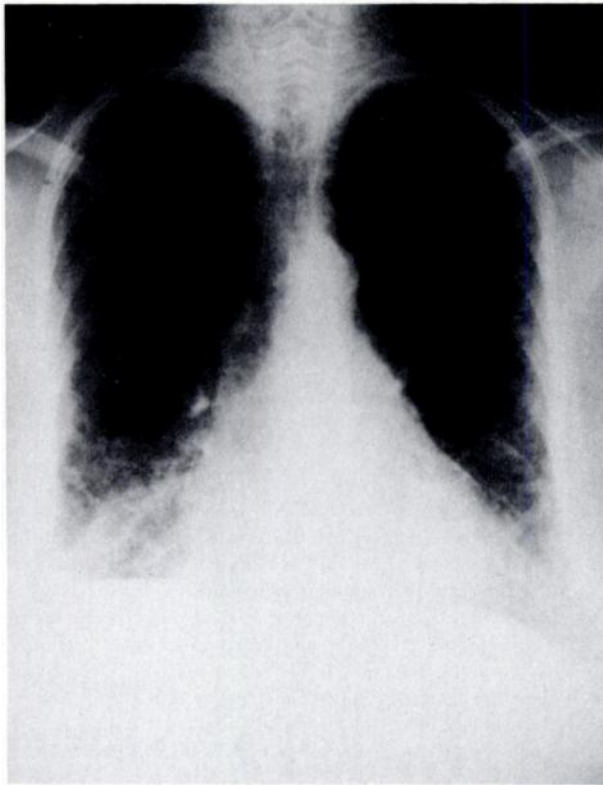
Posteroanterior chest radiograph showing bilateral interstitial infiltrates predominantly in the mid and lower lung fields.
